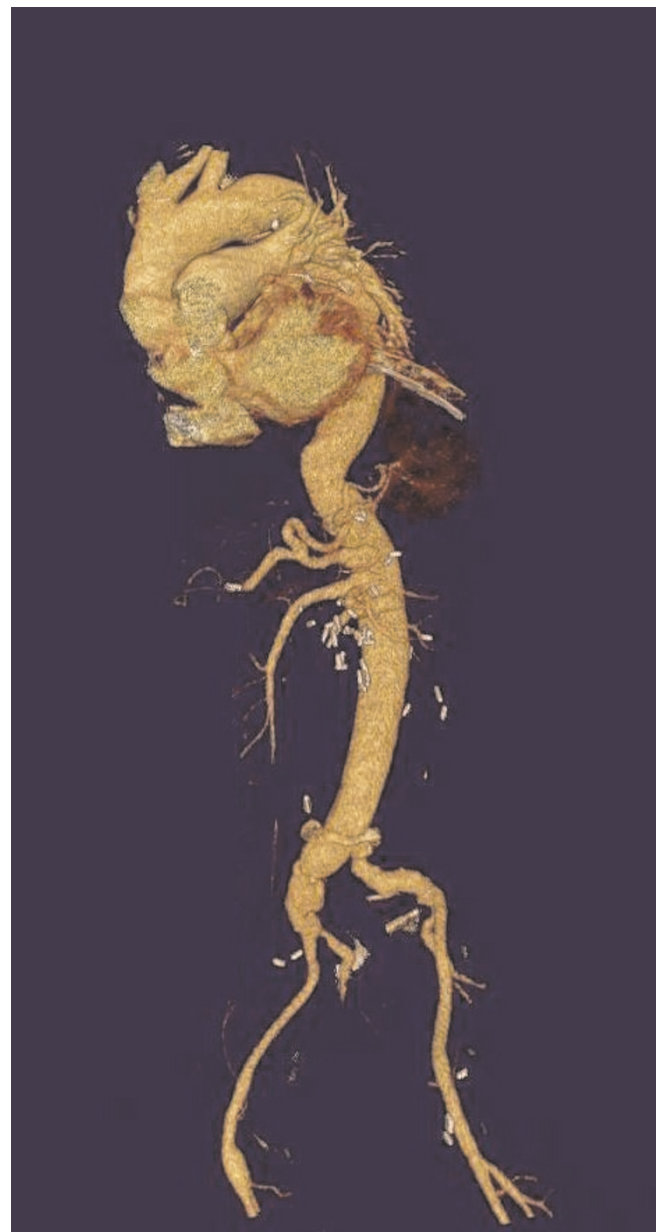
Postoperative Computed Tomographic Angiogram following Crawford Type IV Thoracoabdominal aneurysm repair using the Coselli graft.
